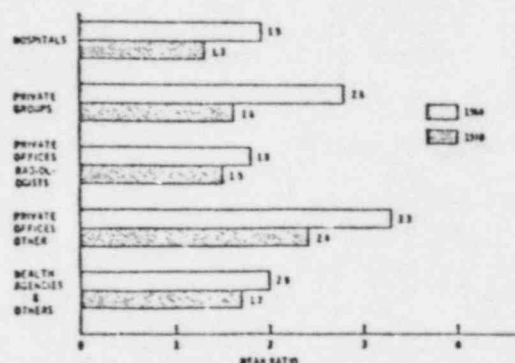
Estimated mean ratio of beam area to film area for radiographic examination by type of facility in the United States, 1964 and 1970. (Preliminary estimates from the USPHS 1970 x-ray exposure study.)
